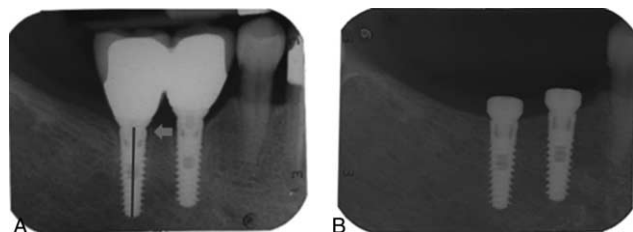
Marginal bone loss measurement. (A) The follow-up radiograph; (B) radiograph after implant placement. Dark gray arrows indicate the level of marginal bone loss; light gray line: calibration according to the known implant's length.
